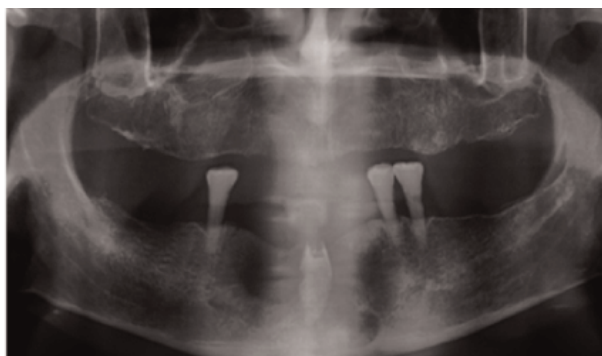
A control panoramic radiograph, 12 months after the intervention
